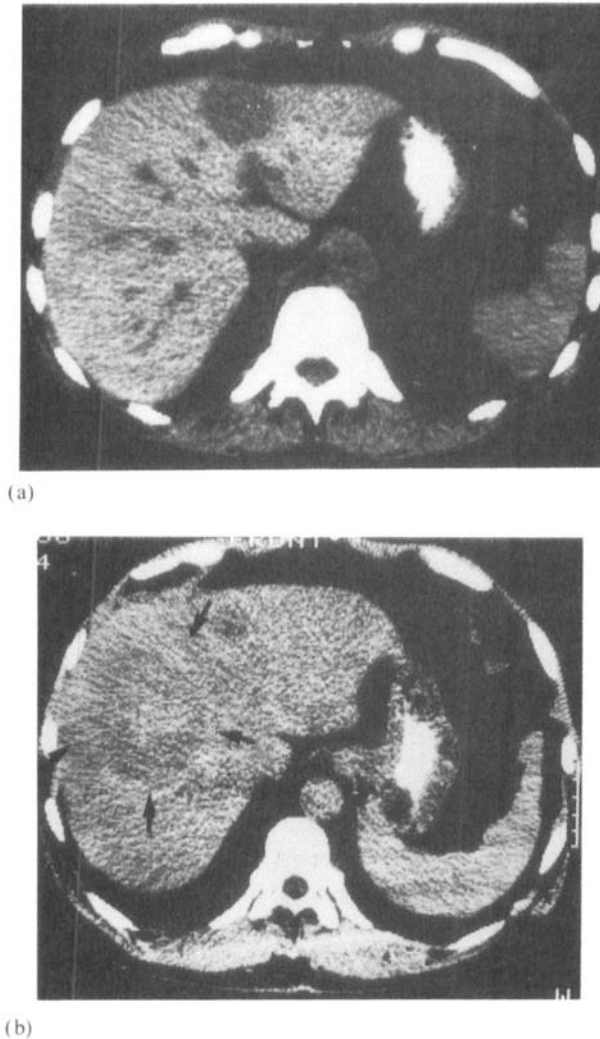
CT images of a) solitary and b) major dominating (arrows) hepatic metastases from midgut carcinoids removed by liver resection.
